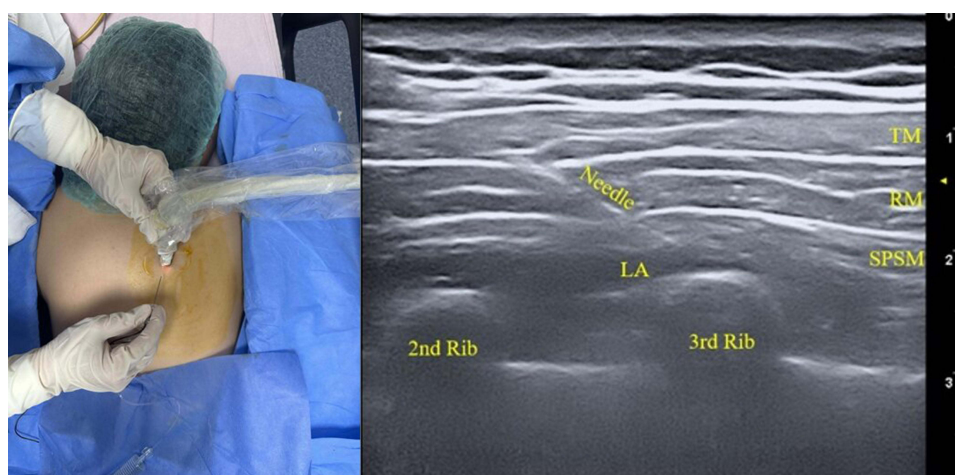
Ultrasound image of SPSIPB application.
